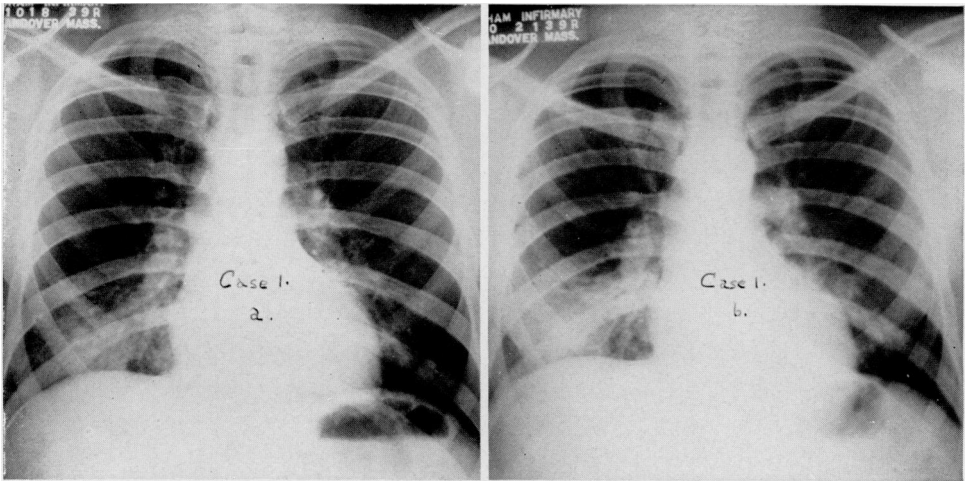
(Case I). X-rays taken on the fifth day of disease (a) and on the eighth day (b), showing the development of a lesion at the base.
